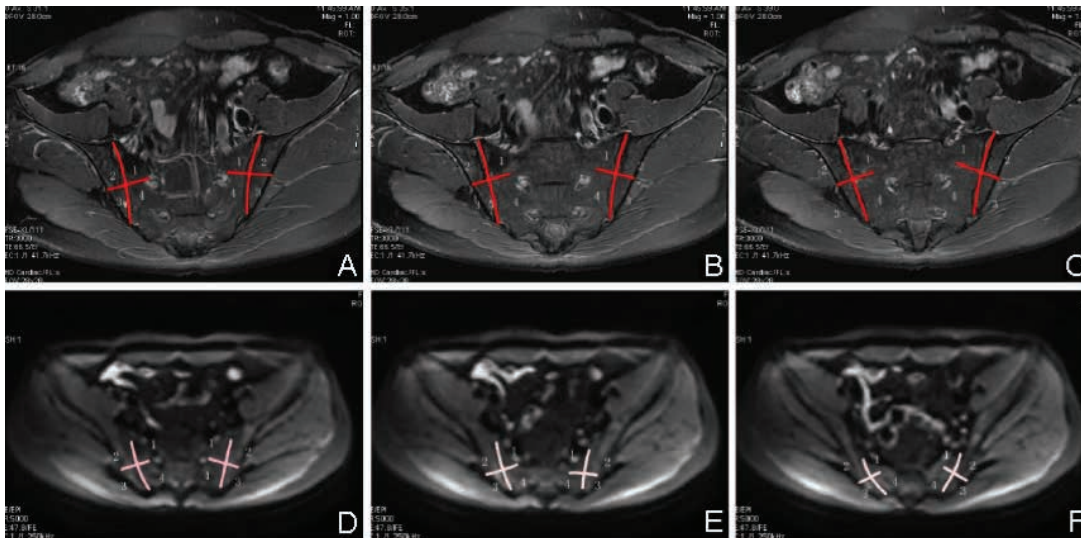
Bone marrow edema scoring on T2WI STIR sequence and DWI sequence in one patient. Bilateral sacroiliac joint was divided into four quadrants (1 supra-sacral, 2 supra-iliac, 3 infra-iliac, 4 infra-sacral), and scoring was performed following the principles above. A, B and C were STIR images, cumulative scoring was 2 points; D, E and F were DWI images, and the cumulative scoring was 15 points. This method could reflect some bone marrow edema which did exist but not shown in STIR sequence.
